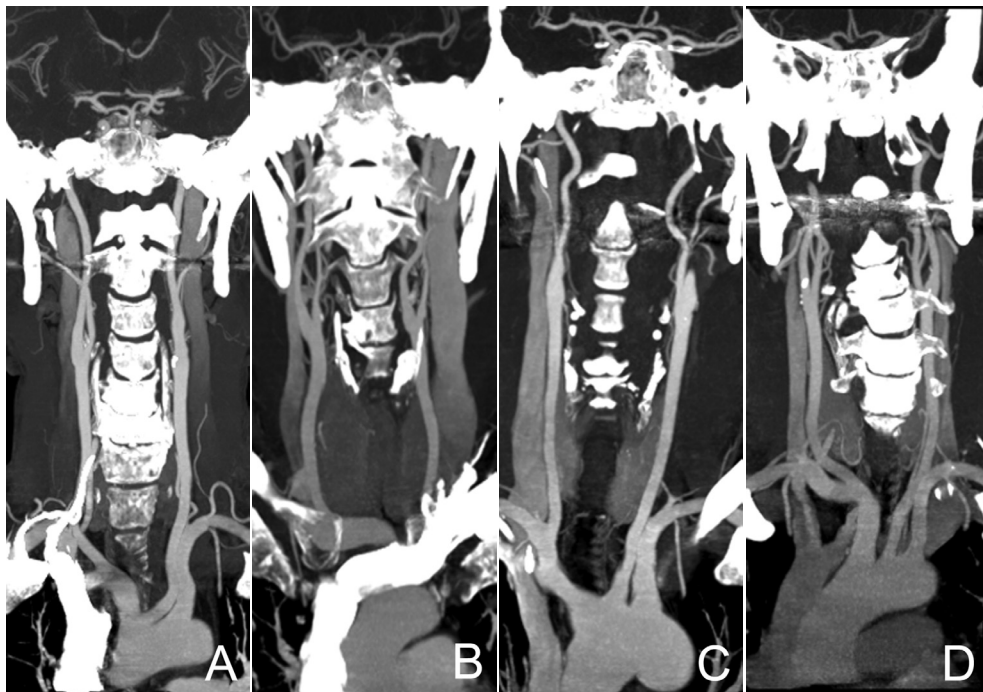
CT angiograms of supra-aortic arteries. Four maximum intensity projections (30 mm) in coronal plane in four patients.
